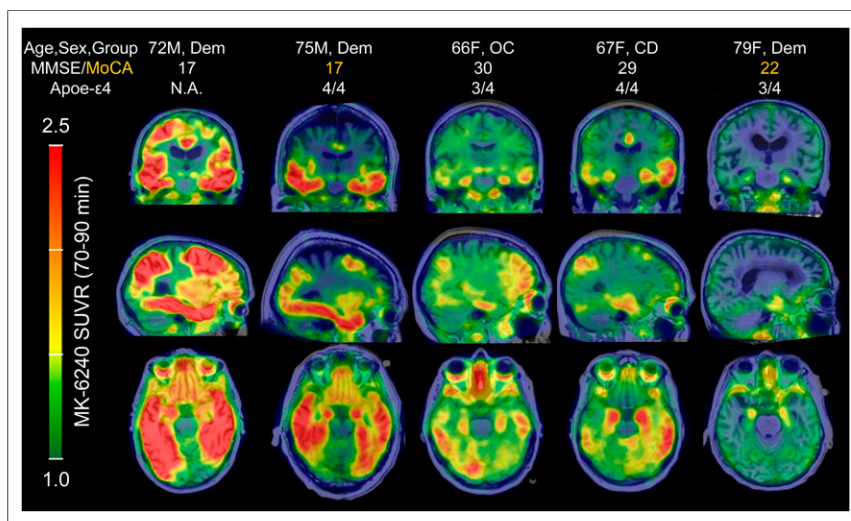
^{18}F -MK-6240 parametric SUVR(70–90 min) images in PiB(+) individuals organized by image-based Braak stages. ^{18}F -MK-6240 spatial binding patterns in PiB(+) individuals recapitulated patterns consistent with neuropathological staging of AD, including in the hippocampus. The PiB(+) dementia patient in far-right column was clinically diagnosed with probable AD dementia (not informed by biomarkers), but exhibited only circumscribed ^{18}F -MK-6240 signal in the entorhinal region. MoCA = Montreal Cognitive Assessment.
